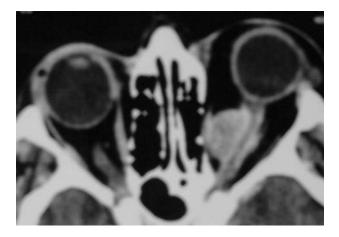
Optic Nerve Sheath Meningioma: CT with iodine contrast: left optic sheath meningioma. This axial view shows the meningioma stems from the nerve sheath itself
